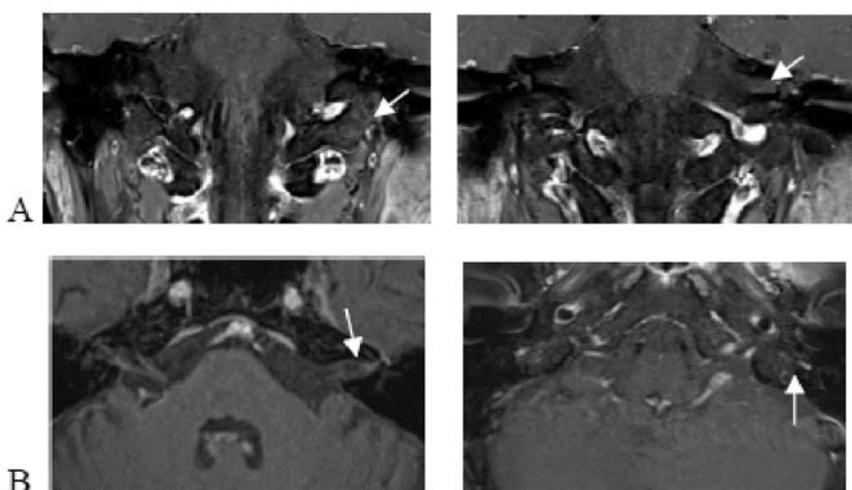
Case 1: Bell's palsy: A 65-year-old male presented with left facial paralysis for 2 days. He had no known underlying disease. Bell's palsy was suspected on the clinical examination. MRI of the brain coronal (A) and axial (B) post gadolinium T1WI demonstrated asymmetrical prominent smooth enhancement of left facial nerve, involving from left distal IAC down to mastoid segment (white arrow).
